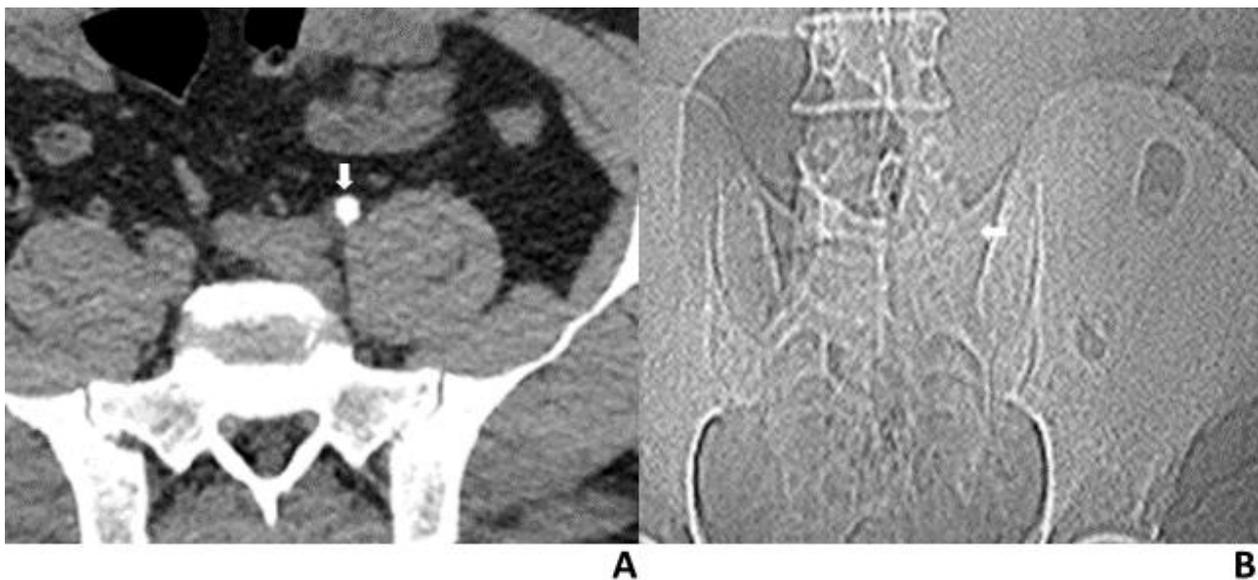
A 39-year-old man with a left ureteral stone. A, axial CT scan shows a left mid-ureteral stone (arrow) measuring 8 mm. B, CT scout radiograph does not reveal a stone. The arrow points to the location of the stone, cross-referenced to axial CT.
